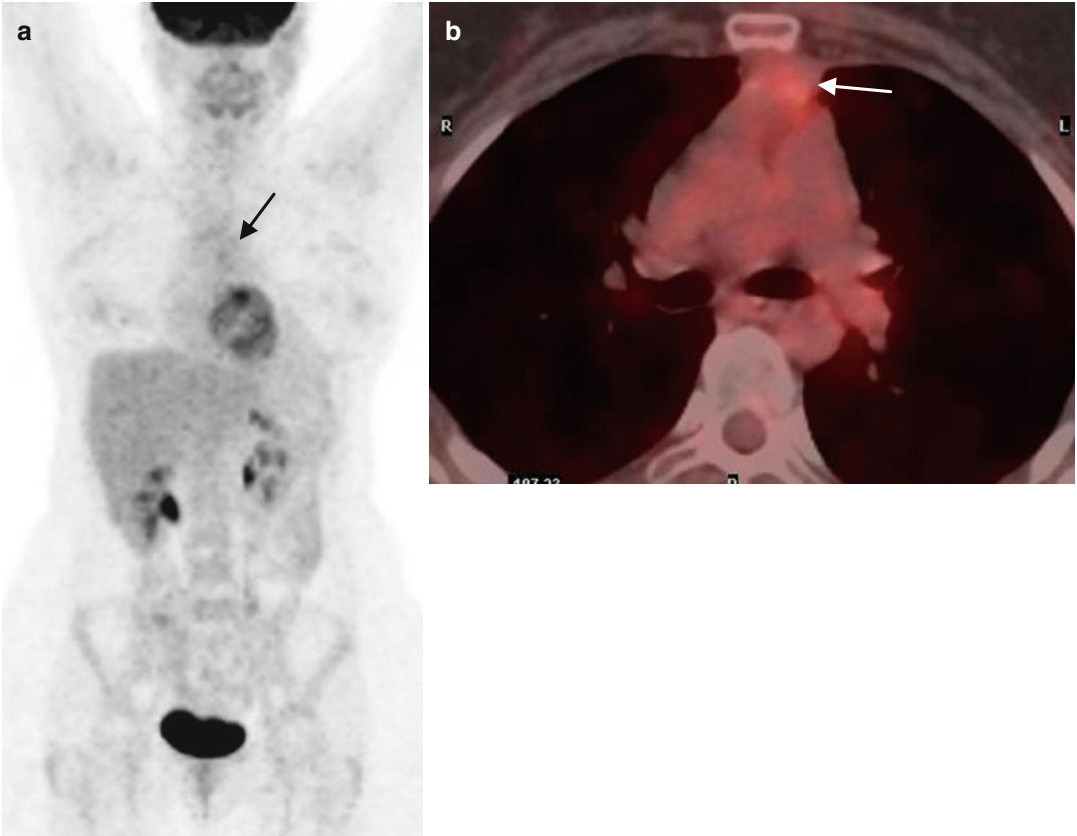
(a, b) MIP-PET and fused PET/CT post RT: Mildly increased FDG uptake (*arrows*), slightly higher than that of the mediastinum but lower than that of the liver (D5-PS score 3)
